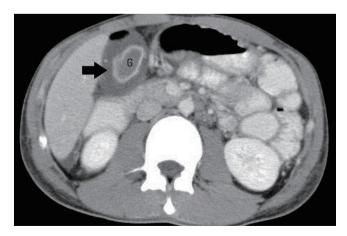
Acalculous cholecystitis with pericholecystic fluid collection as demonstrated by abdominal computed tomography scans. G, gallbladder.
